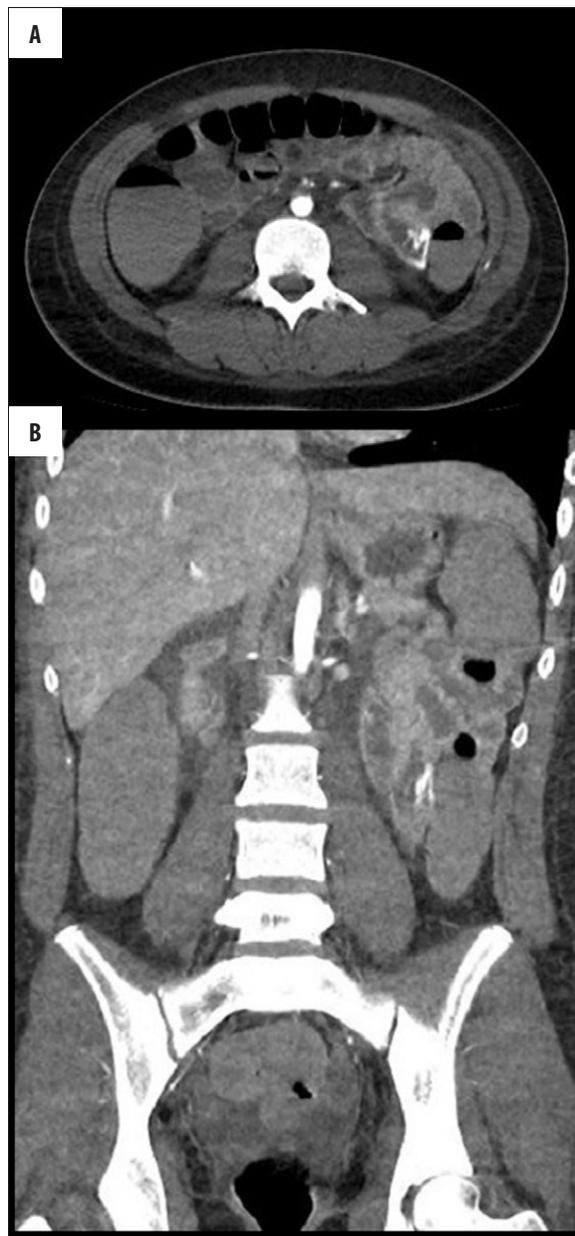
CT angiography – arterial phase. (A) axial, (B) coronal. Extravasation of contrast is observed in one of the jejunal loops
